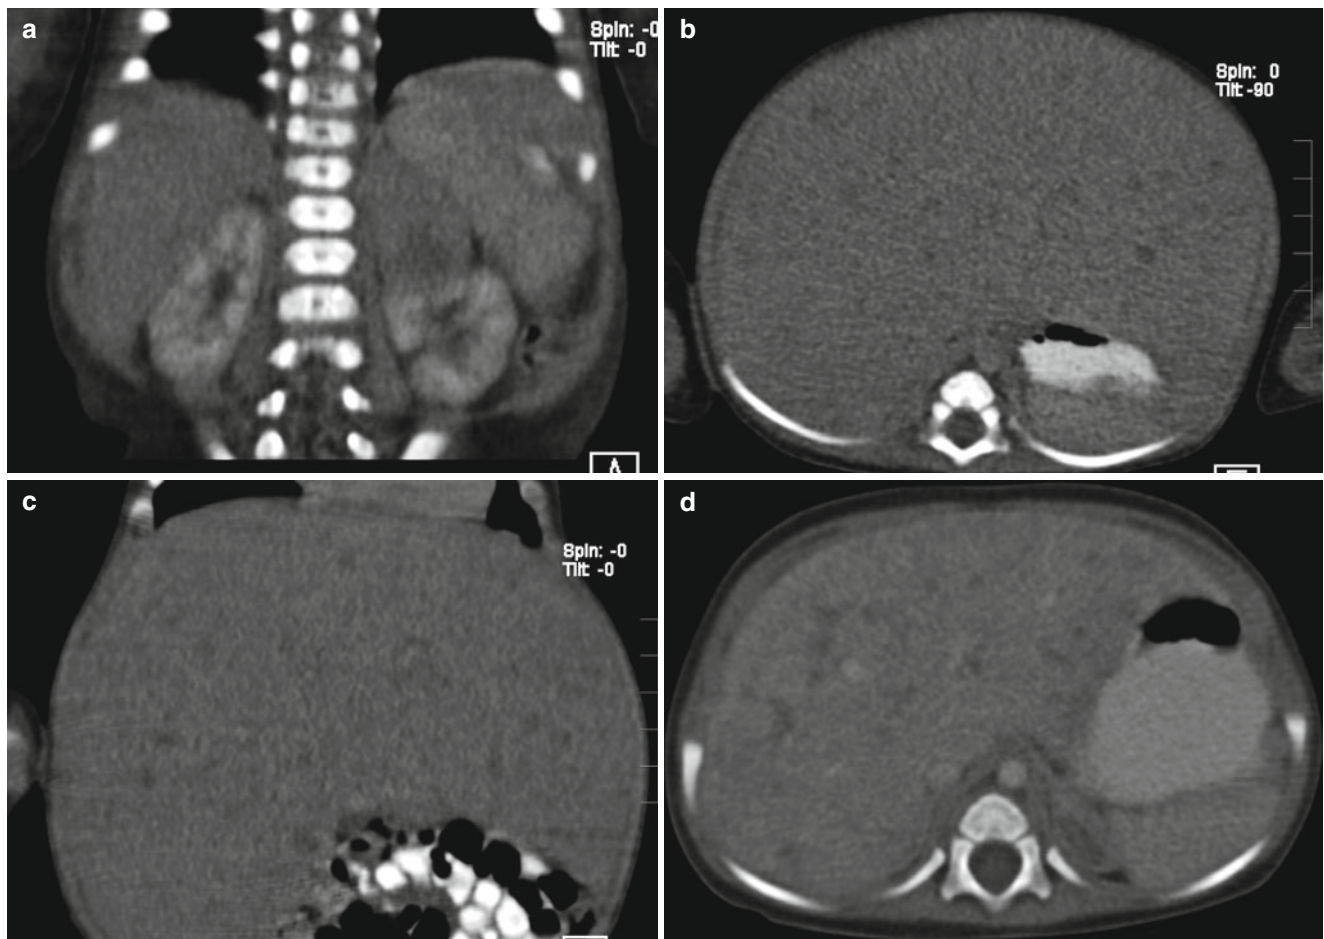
Left adrenal neuroblastoma with multiple liver metastases in a 2-month-old boy. (a) Coronal contrast-enhanced CT image shows the left adrenal mass compressing the left kidney. (b) and (c) Axial and coronal CT images show a diffusely enlarged liver with multiple tiny
